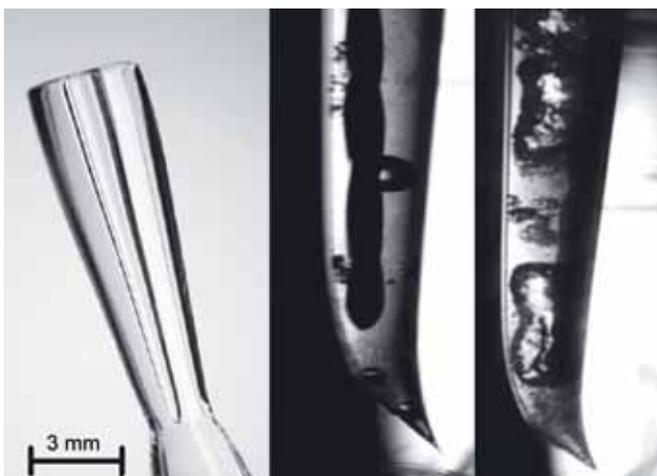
Left: Glass root canal model allowing optical access to the vibrating file for high-speed visualization of ultrasonic irrigation. Middle: File in operation captured at microseconds time scale displaying both transient and inertial cavitation phenomena and, in addition, local streaming patterns (only visible in video mode), right: a high-speed recording of a noncutting K-file is shown, displaying vigorous microstreaming and collapsing cavitation bubbles
